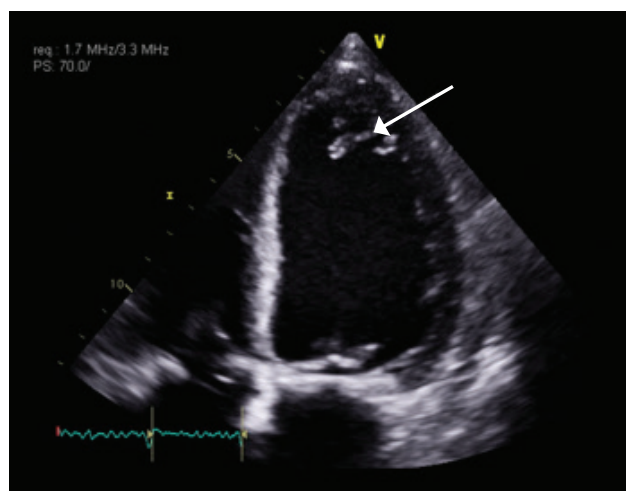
Apical 4-chamber view of the echocardiogram shows dilated LV with apical thrombus (arrow).
